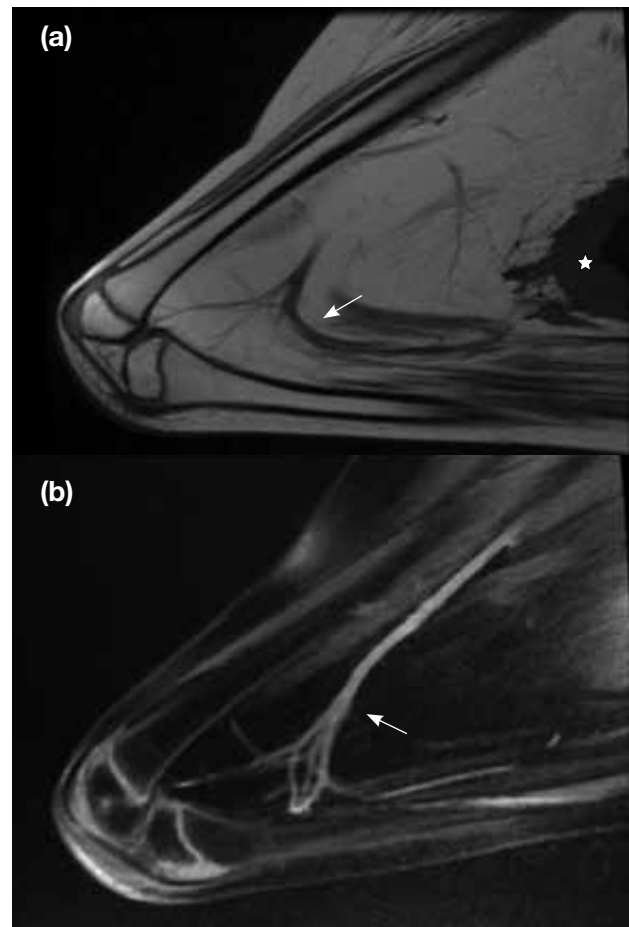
(a) A sagittal T1-weighted magnetic resonance image (MRI) of the left knee, and (b) post-contrast fat-suppressed sagittal T1-weighted MRI of the right knee. These show normal positions of the popliteal arteries (arrows) away from the thickened subcutaneous soft tissue pterygium bands (*).
